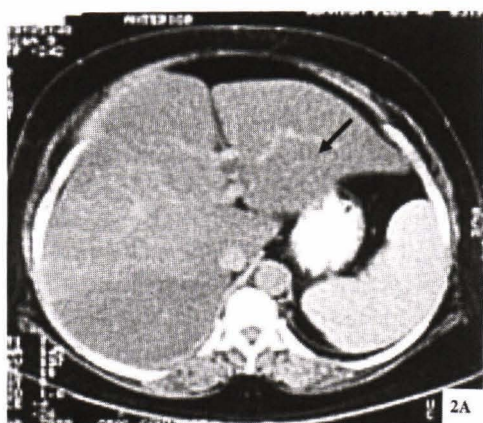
& 2B. CT scan of the liver before (2A) and 4 months after treatment with pioglitazone (2B). Note the decreased attenuation of liver parenchyma, as compared to blood vessels and spleen (Fig. 2A, arrow), indicating hepatic fatty infiltration, which improved after pioglitazone treatment.
